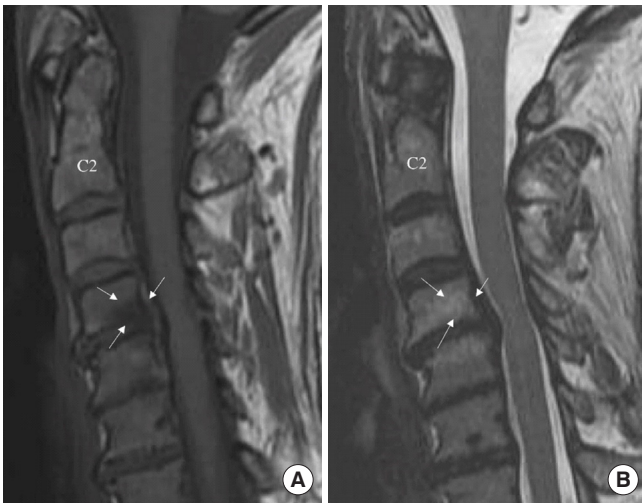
(A) A T1-weighted magnetic resonance imaging (MRI) of a 59-year-old female demonstrating hypointensity at the inferior endplate of C4. (B) A T2-weighted MRI of the same patient demonstrating hyperintensity, suggesting a type I Modic change. She went on to have a 2-level anterior cervical discectomy and fusion procedure of C4–6. Arrows indicate the location of the identified Modic change lesion on T1- (A) and T2-weighted (B) imagings.
